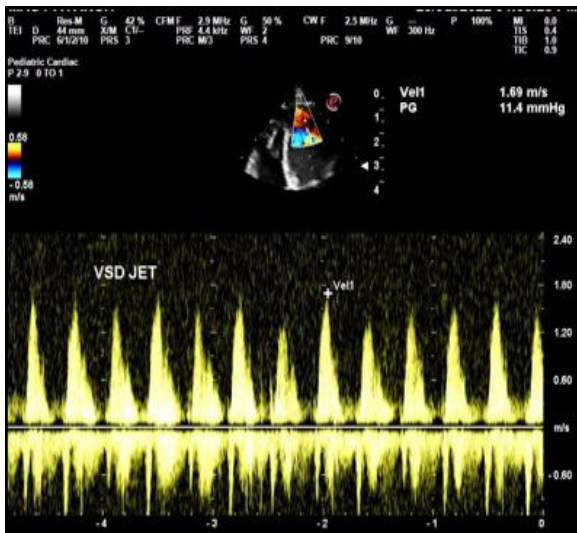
CW Doppler flow across large apical VSD, in our patient.
